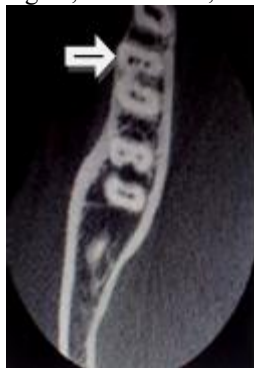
Axial view – PRE CBCT – detecting three mesial canals and two distal canals.
